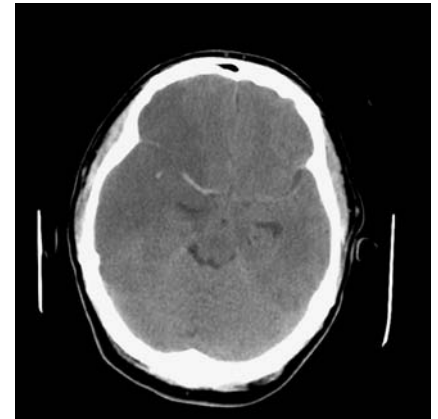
Computed tomography head scan showing middle cerebral artery occlusion with associated cerebral infarction and oedema 24 hours after symptom onset. Thrombolysis had been given 2 hours 40 min after presentation, without benefit.
